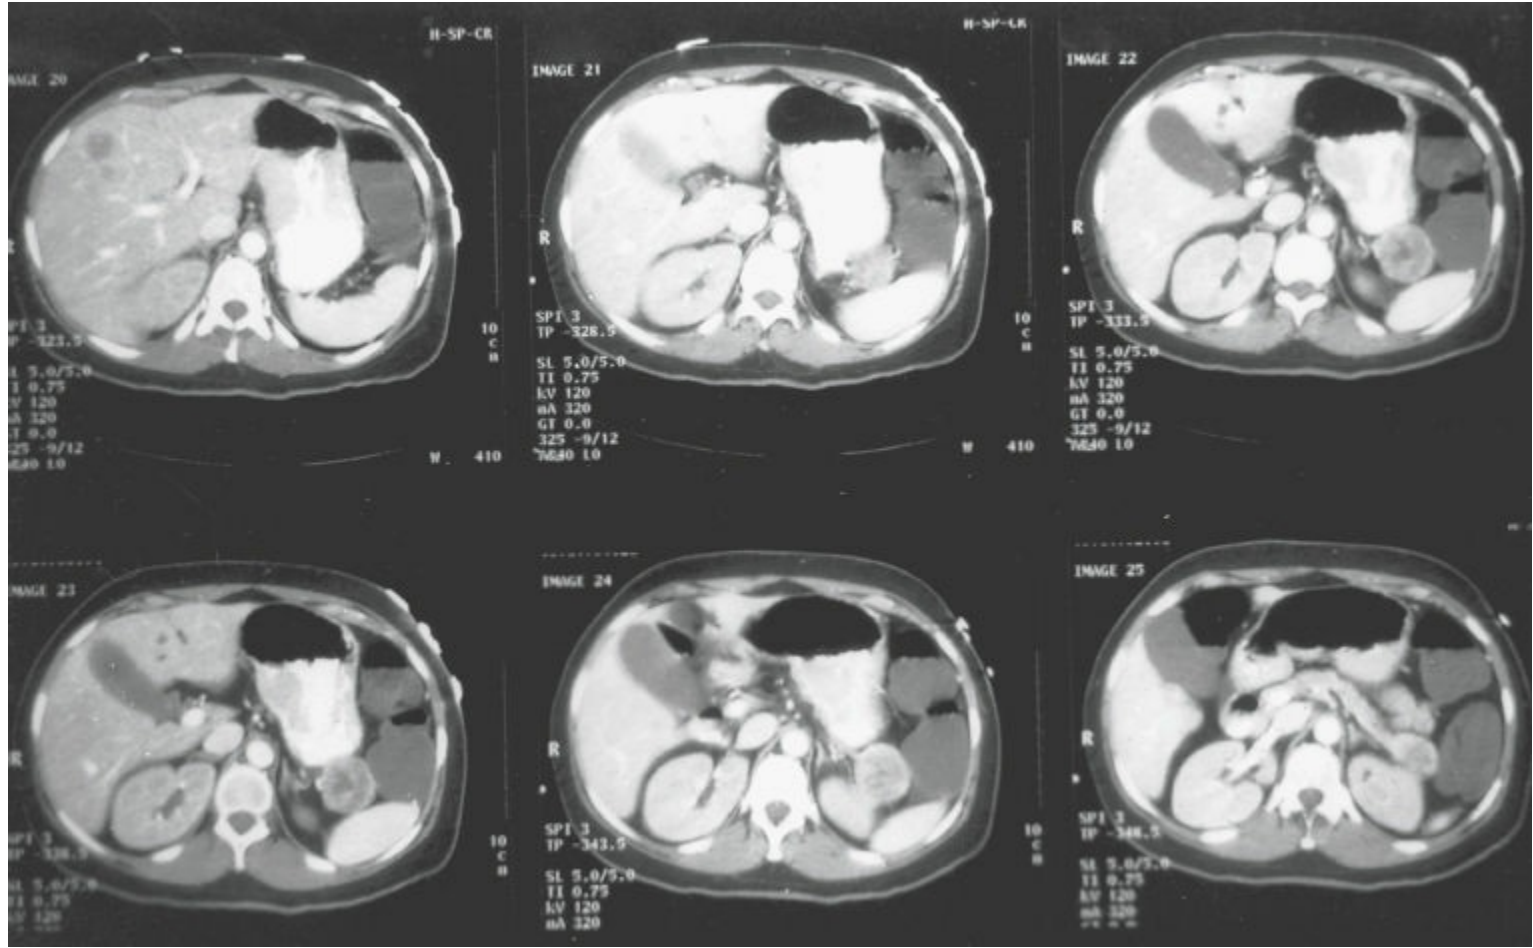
Several computed tomographic images from a patient with a primary vasoactive intestinal polypeptide-oma (VIPoma) in the tail of the pancreas. The tumor is nearly spherical. Its location is posterior to the stomach and adjacent to the spleen.
